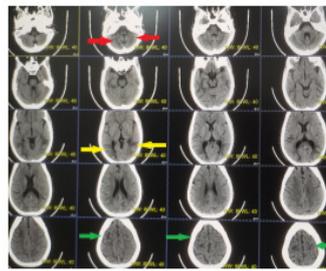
Axial CT images showing hypodensity in cerebellar white matter (red arrow), parieto-occipital white matter (yellow arrow) and superior / inferior frontal lobe (green arrow).
